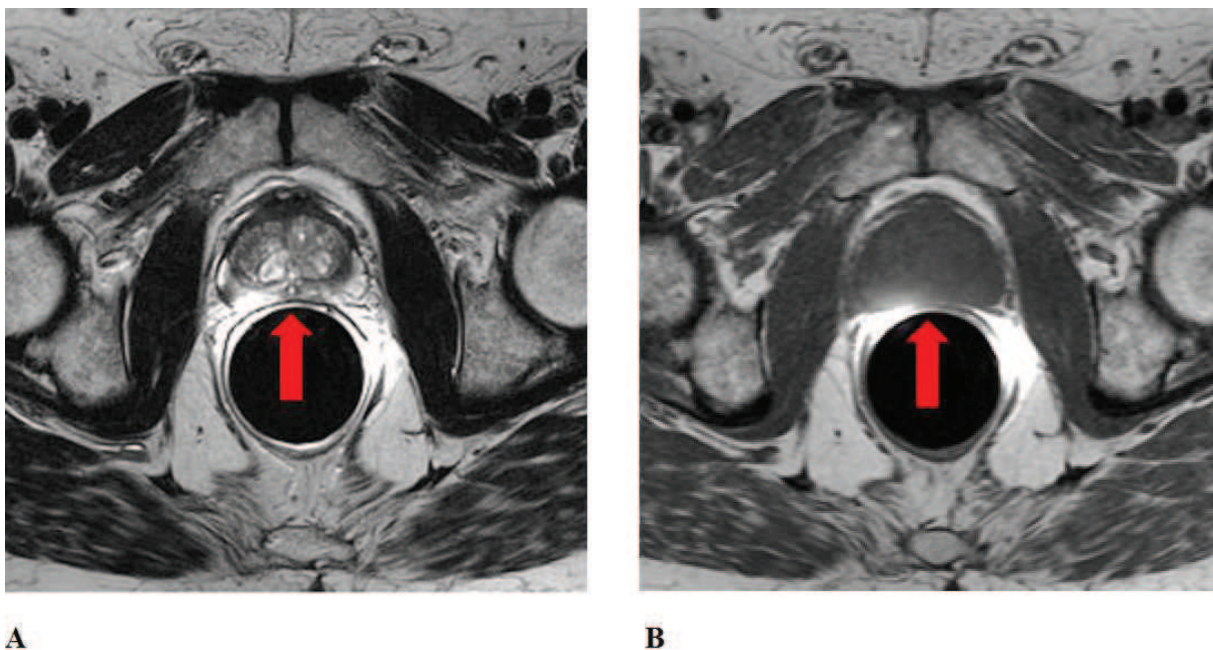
MRI scans of a human prostate with a cancerous lesion: (A) Axial T1-weighted and (B) axial T2-weighted images. The red arrows point at the malignant neoplasm, which is located in the peripheral zone [17].
